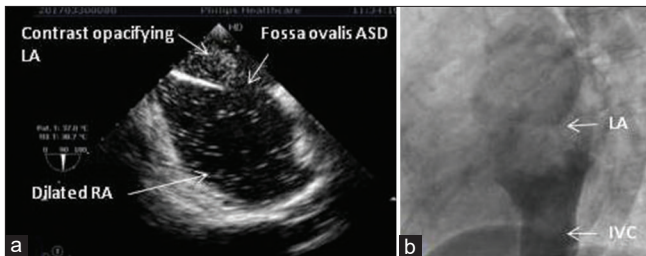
(a) Transesophageal echocardiogram with agitated saline contrast injected into a vein in the lower limb, densely opacifying the left atrium. The dilated right atrium is opacified via the atrial septal defect. (b) Left lateral angiogram showing a posteriorly placed inferior vena cava draining to the posteriorly located left atrium, adjacent to the spine
